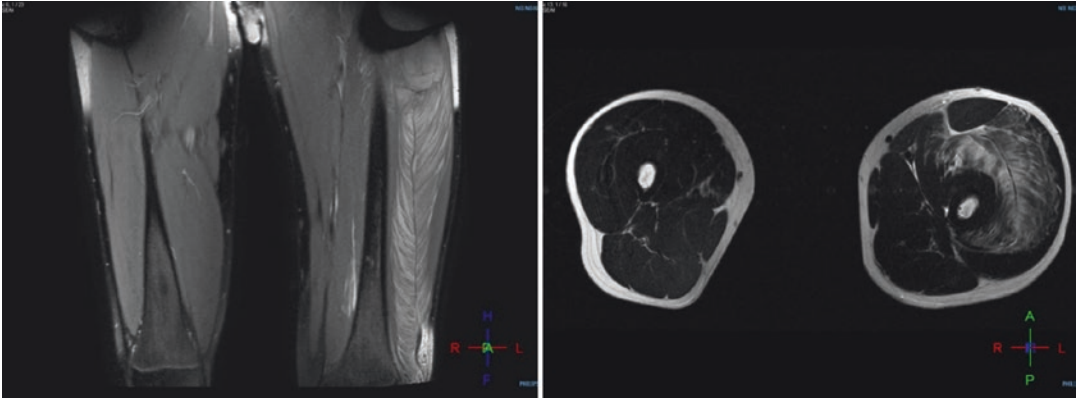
MRI image (normal and injured muscle)
